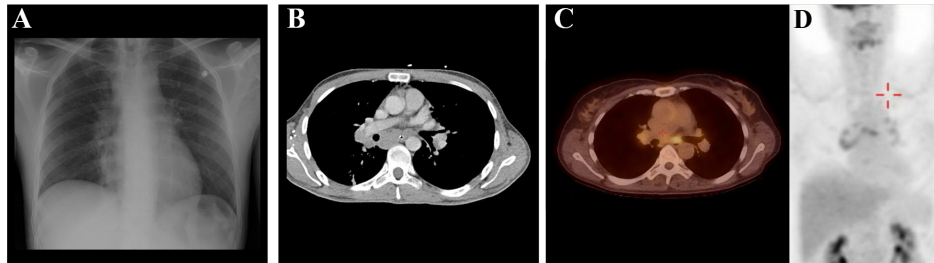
Abnormalities suggestive of neurosarcoidosis on systemic imaging. Abnormalities suggestive of sarcoidosis on systemic imaging consisting of hilar lymphadenopathy on chest X-ray (A), hilar and mediastinal lymphadenopathy on chest CT-scan (B), and hilar and mediastinal FDG activity on ^{18}F -FDG PET-CT (C and D).
